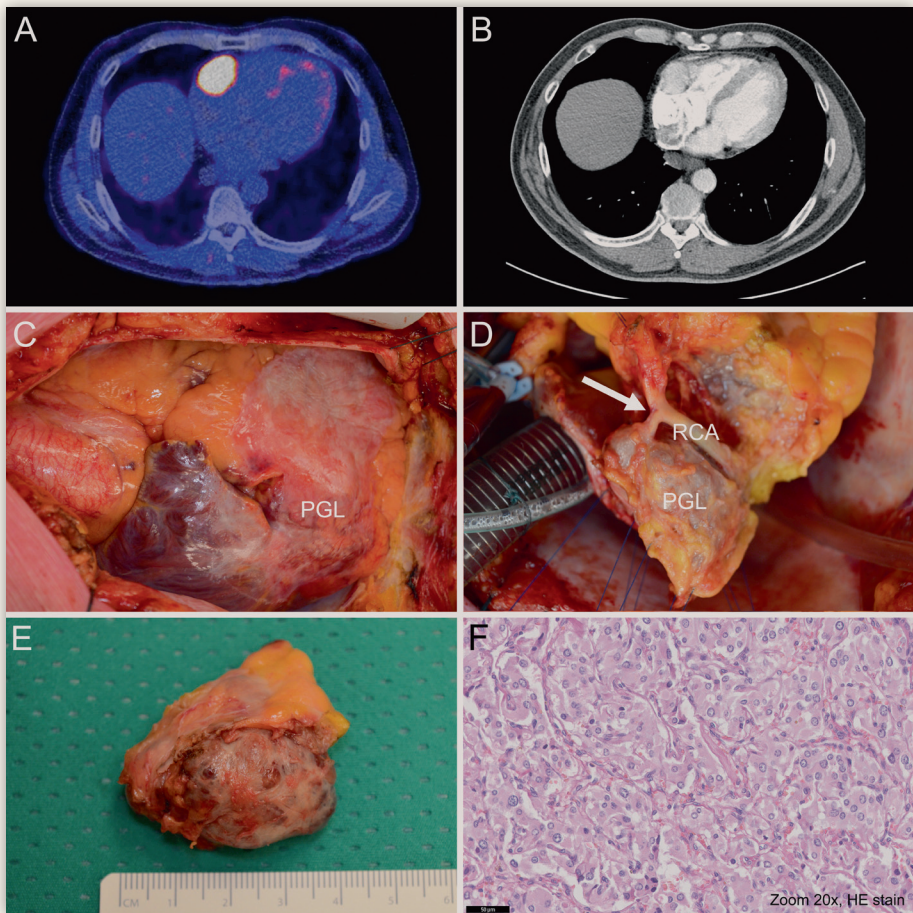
59-year-old man with cardiac paraganglioma (18F-DOPA-PET in A; CT in B) and elevated plasma normetanephrine underwent resection. Vascularization from the right coronary artery (RCA) (C,D) was clipped and transected (E,F). Recovery was uneventful. Cardiac paraganglioma are rare and no cases have been described with direct vascularization from the RCA. DOPA: dihydroxyphenylalanine; PET: positron emission tomography; CT: computed tomography; PGL: paraganglioma.
